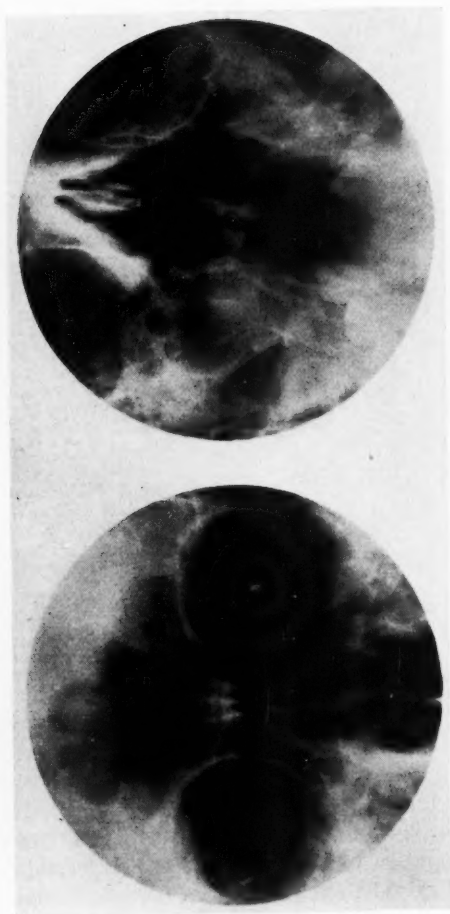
Caseous mass is not shown in the roentgenogram (Case 5).
